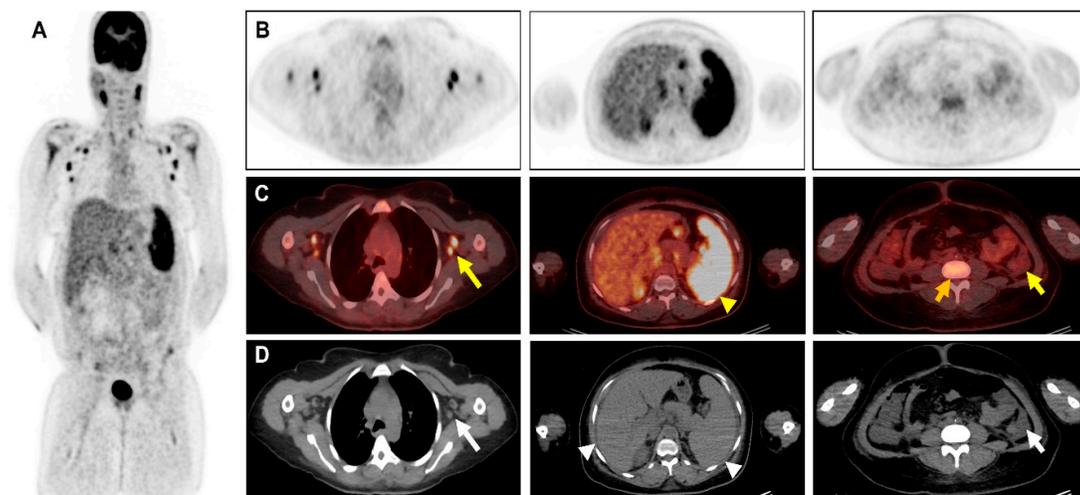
^{18}F -FDG-PET/CT of the patient: (A) Maximum Intensity Projection image (MIP) of the chest, upper and lower abdomen respectively (left to the right), (B) PET images, (C) fused PET/CT images, (D) CT-images. A 44-year-old Mauritanian woman without significant pre-existing medical and recent traveling history presented with tiredness, and febrile non-bloody diarrhoea for 3 weeks. No other complaints. Physical examination revealed left cervical adenopathy, anasarca, and mild splenomegaly. Laboratory tests showed non-regenerative anaemia (5.5g/L), hypoplakettosis (23,000/ μL), elevated serum concentration of C-reactive protein (121mg/dL), direct Coombs positive without acute haemolysis. Extensive work-up for infections (viral, bacterial, and fungi) and autoimmune diseases were also negatives. A thoracoabdominal scanner was realized and showed slightly enlarged cervicothoracic adenopathy (large white arrow), hepatosplenomegaly (head white
